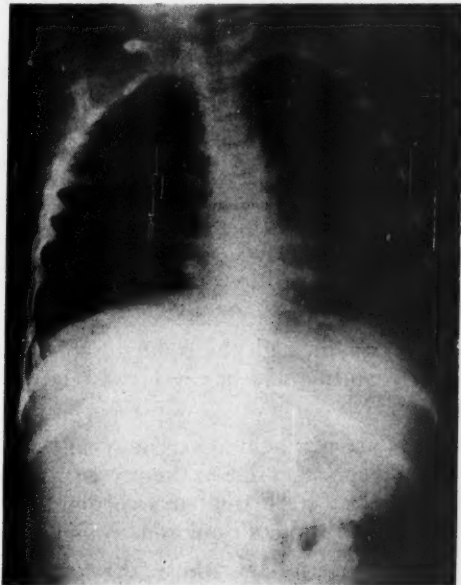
Showing complete expansion of right lung and no fluid. The heart and mediastinum are now in normal position. X-ray was taken 5 months after operation. The patient had gained 8 pounds.
